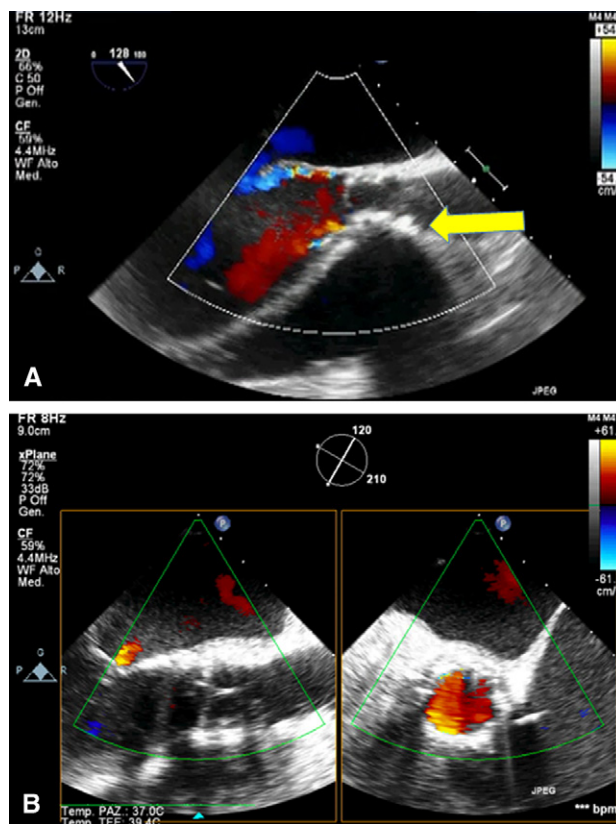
Intraoperative transesophageal images. A, Intraoperative transesophageal echocardiographic image showing the calcified aortic root (arrow). B, Intraoperative transesophageal echocardiographic image showing good positioning of the Sapien XT valve (Edwards Lifesciences, Irvine, Calif) without aortic regurgitation.
